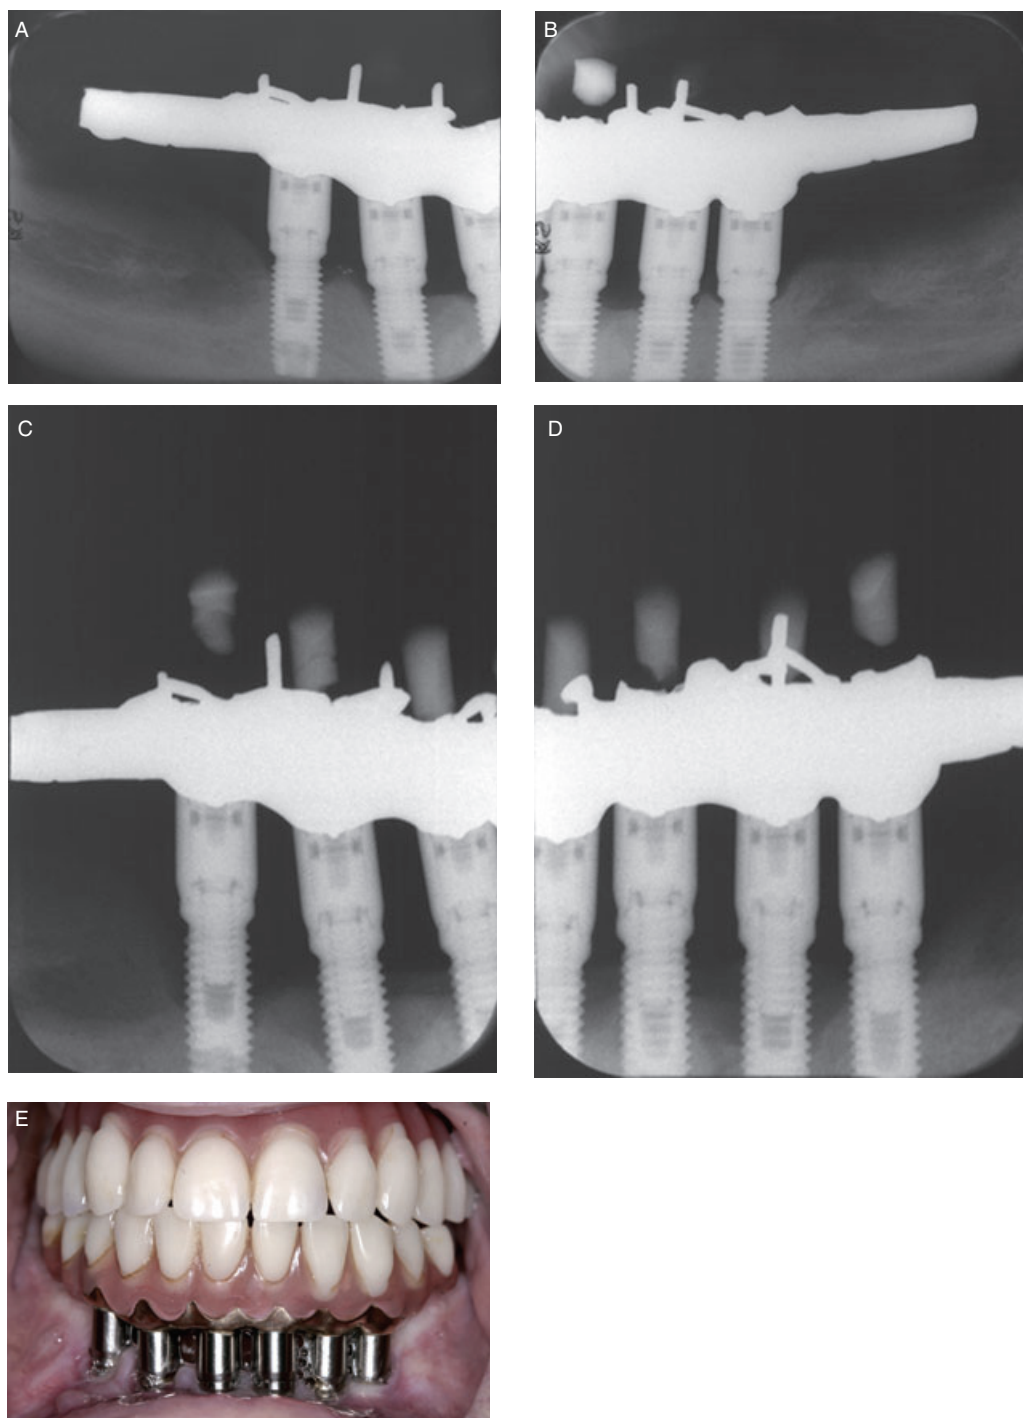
Radiographs of patient number 13 in connection with the treatment 1985 (A and B) and at the 20-year follow-up (C and D). At the implants in positions H2 and V2, craterform bone losses are seen. As both these implants had bleeding on probing at the lingual surface, they were considered as cases of peri-implantitis. In spite of this, the soft tissues looked mainly healthy (E).
